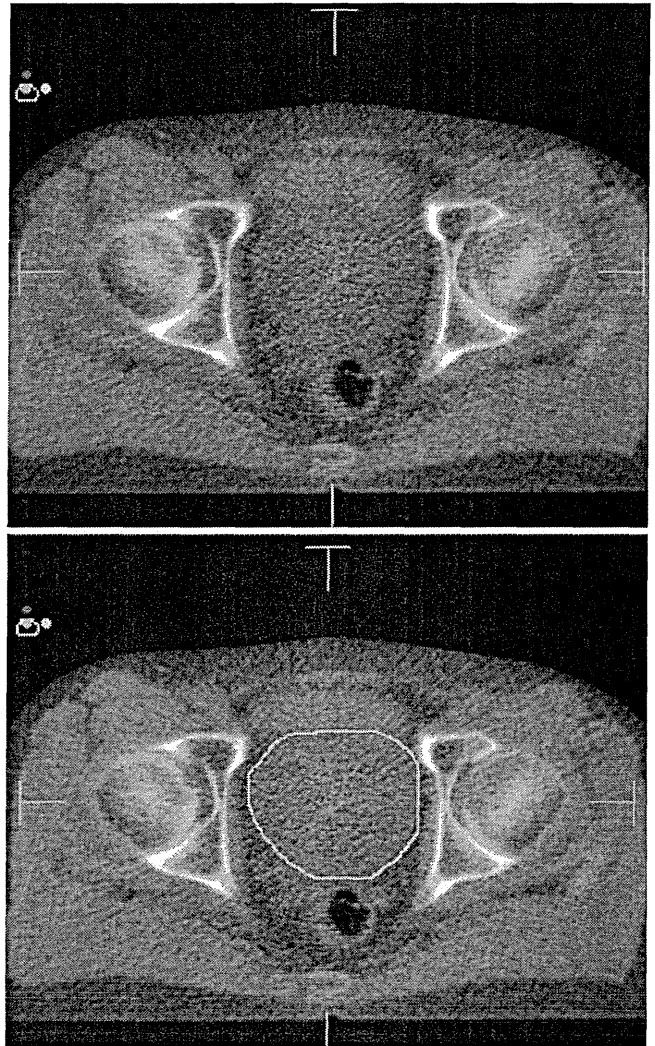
An example of mega voltage computed tomography (MVCT) imaging.
